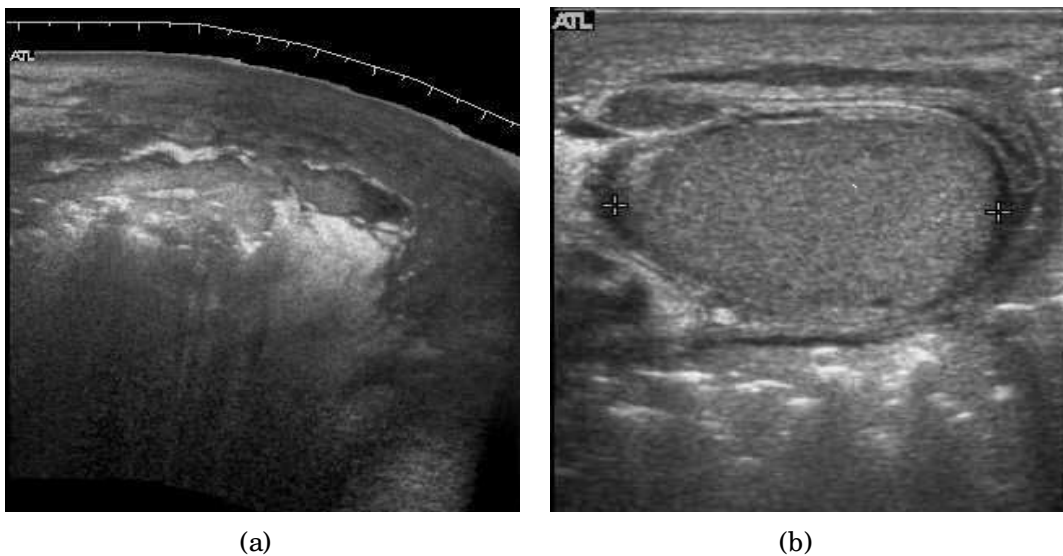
Fournier gangrene. (a) Transverse sonography image shows echogenic areas with dirty shadowing representing air in the perineum. (b) Gas presented as numerous, discrete, hyperechoic foci with reverberation artifacts are seen at scrotal wall
